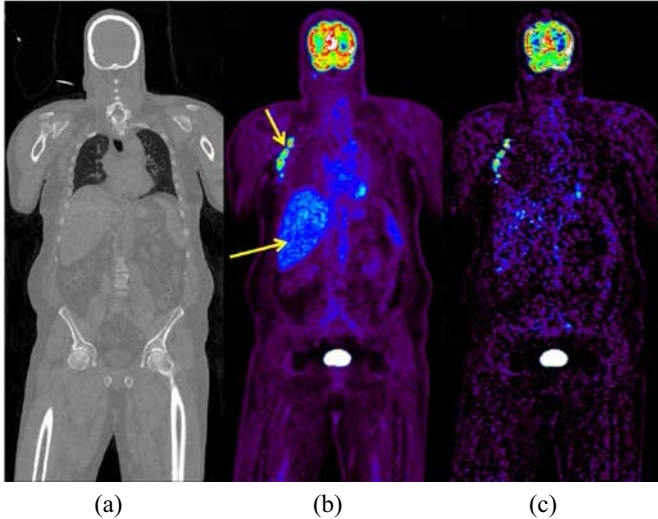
Images of  $^{18}\text{F}$ -FDG in a cancer patient. (a) CT scan. (b) SUV image showing FDG uptake. The lymphoma (upper arrow) has an SUV of 8.9 and the normal liver shows an SUV of 3.2. (c) Parametric image of net uptake constant  $K_i$ . Parametric image of uptake rate constant  $K_1$  with tumor having value of  $28 \mu\text{L}/\text{min}/\text{cm}^3$  and the liver having  $3.9 \mu\text{L}/\text{min}/\text{cm}^3$ .
